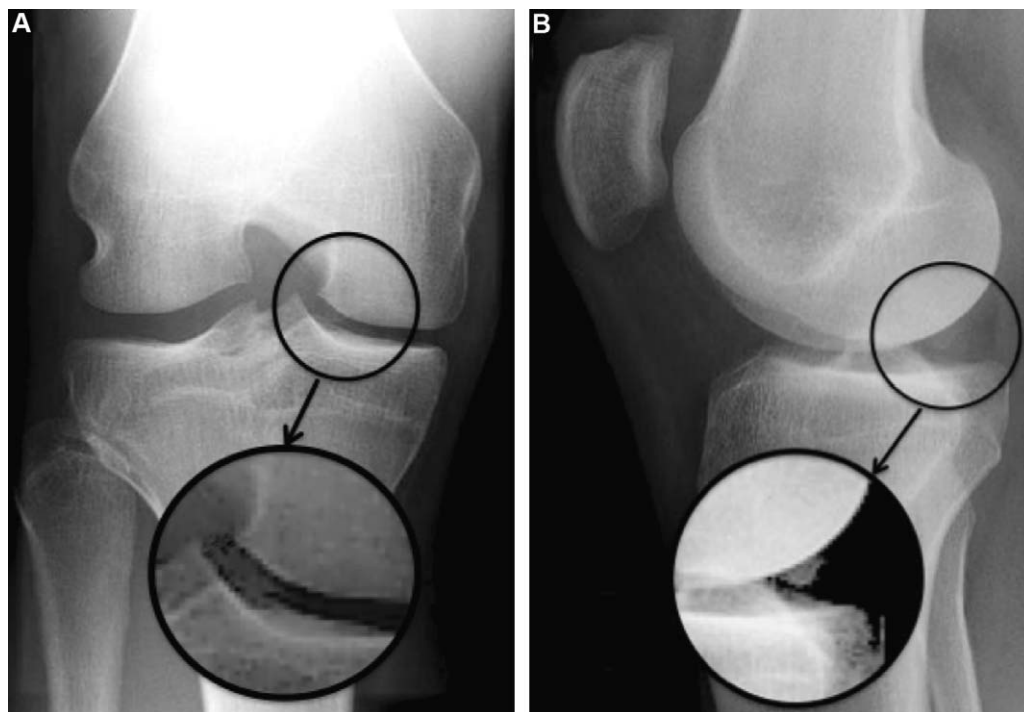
A and B: anteroposterior and lateral radiographs with a small bone fragment at the posteromedial aspect of the knee.
